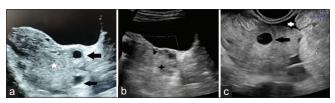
Ultrasonography (USG) images. (a) Transabdominal USG shows an enlarged left ovary with central echogenic stroma (white asterisk) with peripherally placed follicles (solid arrows), (b) Transabdominal color Doppler USG shows the absence of any color flow in the ovary (black diamond), (c) Transvaginal USG shows enlarged ovary with an echogenic rim around follicle – "follicular ring sign" (solid arrow). Free fluid is also seen (white asterisk)
